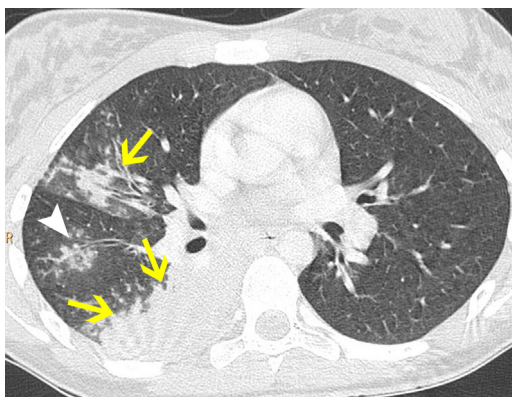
Aspergillosis. CT image shows a homogeneous consolidation of the apical segment of the right lower lobe (arrow). Note the presence of a few tree-in-bud opacities nearby the consolidation (arrowhead). A focal consolidation is also visible in the middle lobe (arrow).
